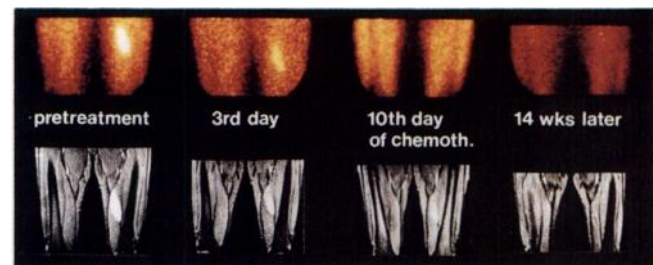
FDG scintigraphy and MRI in a patient previously treated for non-Hodgkin's lymphoma, presenting with pain in the left thigh. There was no palpable mass, CT was negative. MRI and FDG clearly depicted the tumor. Within days after the start of chemotherapy, profound metabolic changes were observed exceeding changes in volume and signal intensity. A complete remission was achieved after completed chemotherapy.
